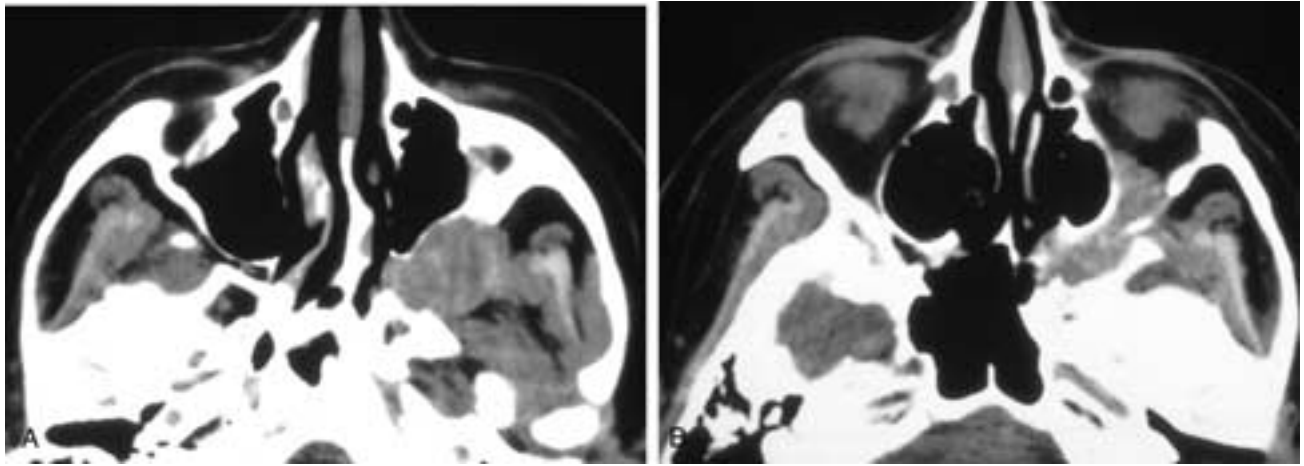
Axial CT scans show a mass in the left pterygopalatine and infratemporal fossae that has both thinned and remodeled the posterior antral wall (A). The tumor has extended up into the left orbital apex and the skull base (B). This patient had an adenoidcystic carcinoma.
